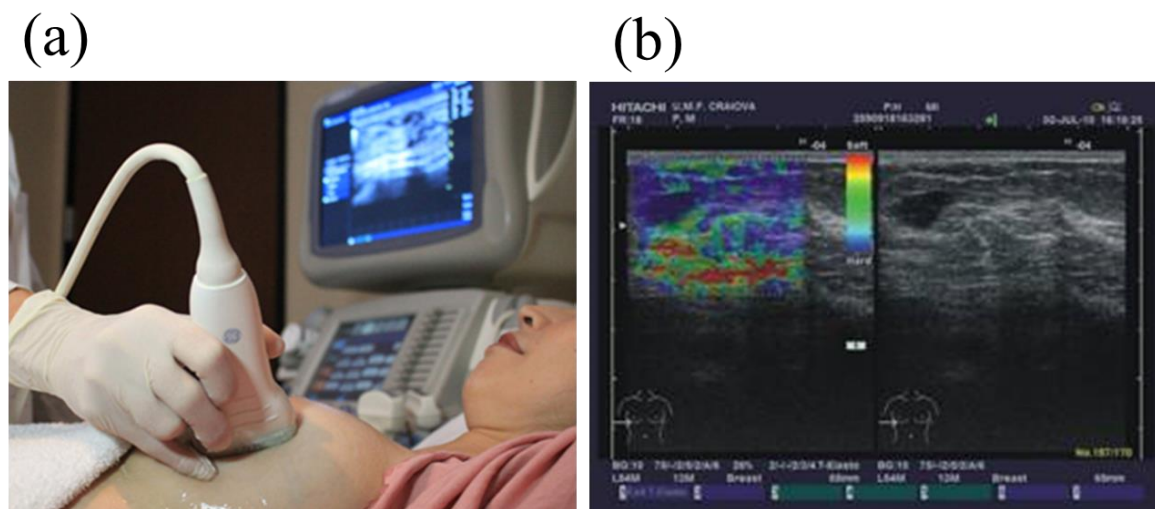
(a) US Equipment, (b) Ultrasound elastography of ductal invasive carcinoma in a 51 year old patient with blue elastic appearance and desmoplastic reaction [51]
